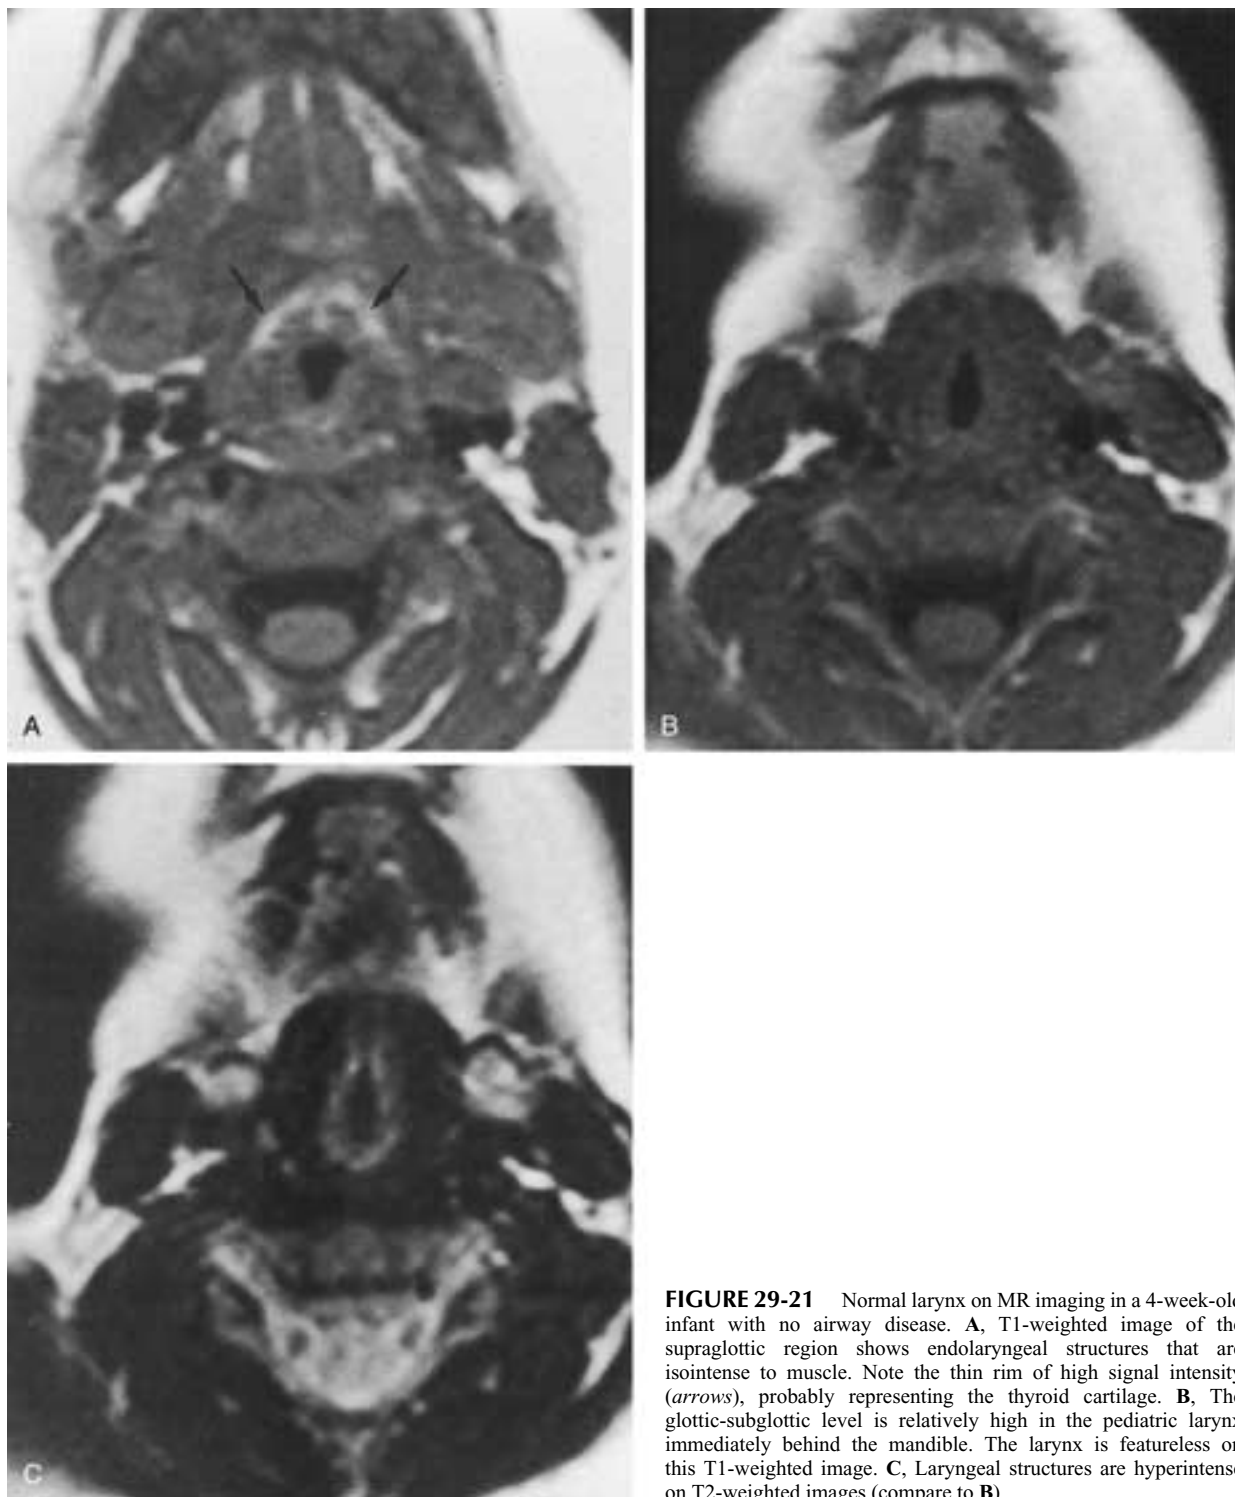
Normal larynx on MR imaging in a 4-week-old infant with no airway disease. A, T1-weighted image of the supraglottic region shows endolaryngeal structures that are isointense to muscle. Note the thin rim of high signal intensity (*arrows*), probably representing the thyroid cartilage. B, The glottic-subglottic level is relatively high in the pediatric larynx immediately behind the mandible. The larynx is featureless on this T1-weighted image. C, Laryngeal structures are hyperintense on T2-weighted images (compare to B).
